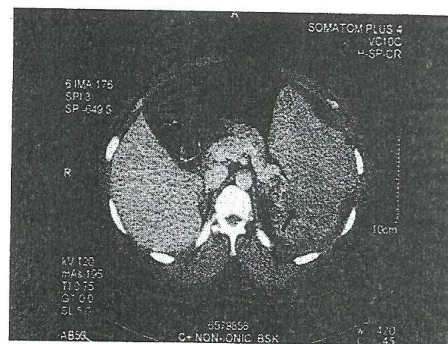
Figure Axial CT image shows Sickle cell disease [Mayr kur 2009]
